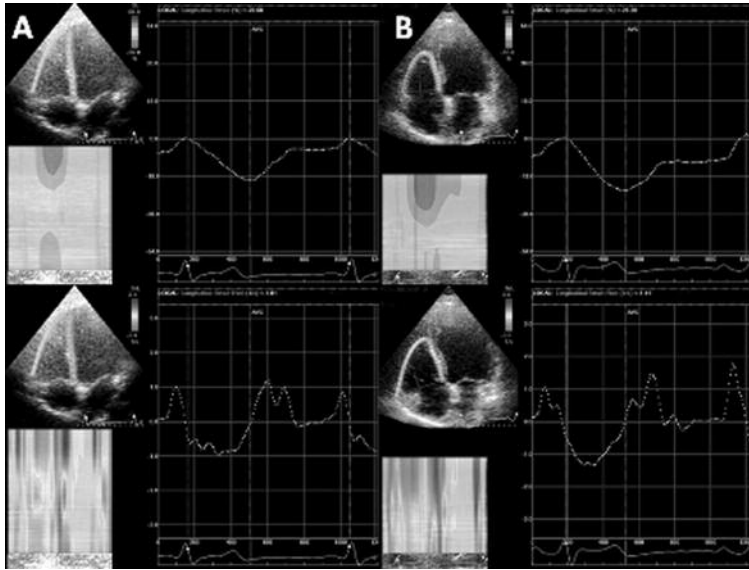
Example of a two-dimensional strain (above) and strain rate (below) measurement of the right ventricle (RV) in a patient with right coronary artery chronic total occlusions who underwent percutaneous coronary intervention (PCI); before (A) and after (B) successful PCI. Apical four-chamber view is shown. The dotted curve is the RV global longitudinal strain and strain rate. The mean RV global peak longitudinal strain and systolic strain rate before and 24 hour-after successful PCI were -20.16% vs -25.38% , and -1.01s^{-1} vs -1.41s^{-1} , respectively.
